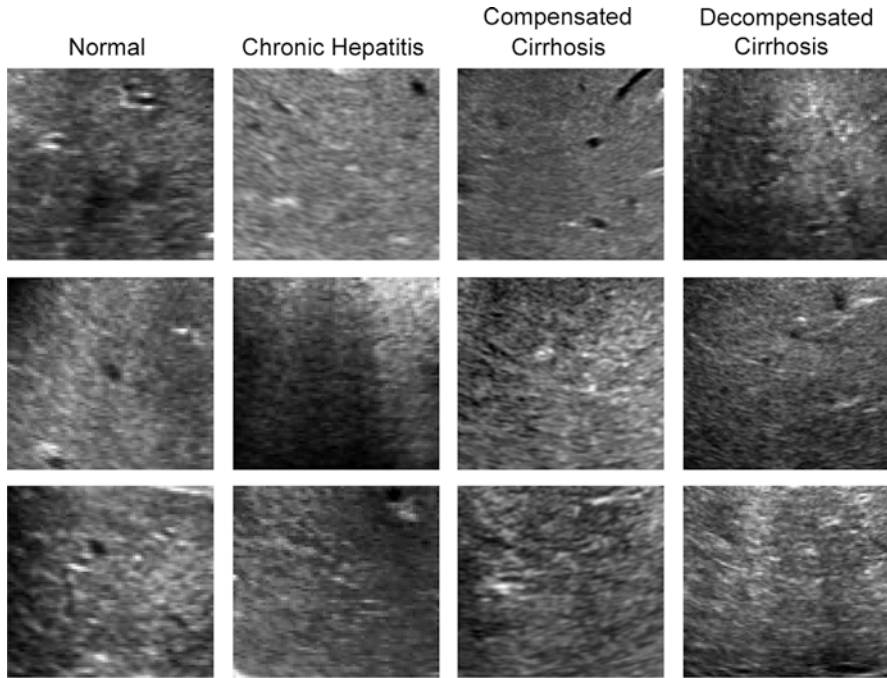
Ultrasound images variability in the different stages of chronic liver disease
